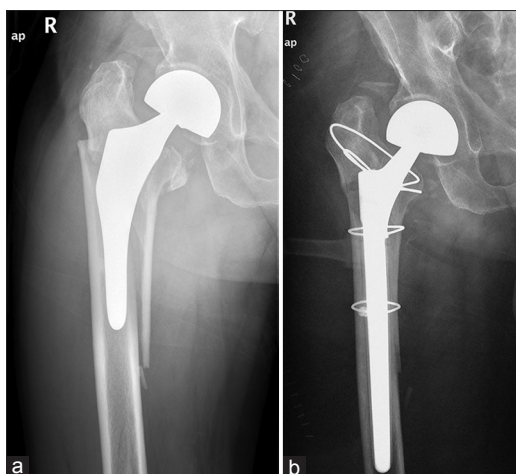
X-ray of right hip joint (anteroposterior view) showing (a) Vancouver B3 periprosthetic femoral fracture in a 76-year-old male patient (b) A revision hemiarthroplasty was performed and multiple cerclage were used to stabilize proximal fracture of the femur
